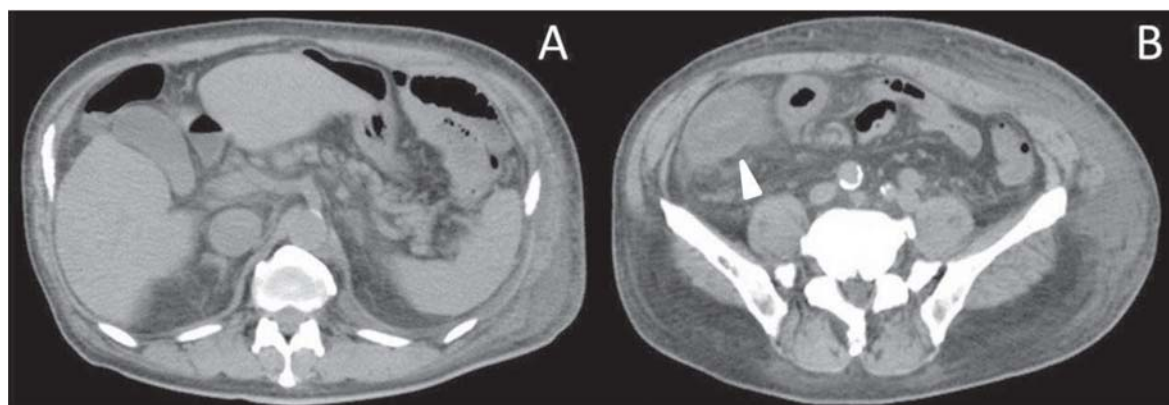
Abdominal CT scan 3 days after operation resulted in disappearance of inferior vena cava gas and hepatic portal vein gas (A), and thickness of the wall at the ileocecal bowel was revealed (white arrow) (B).
